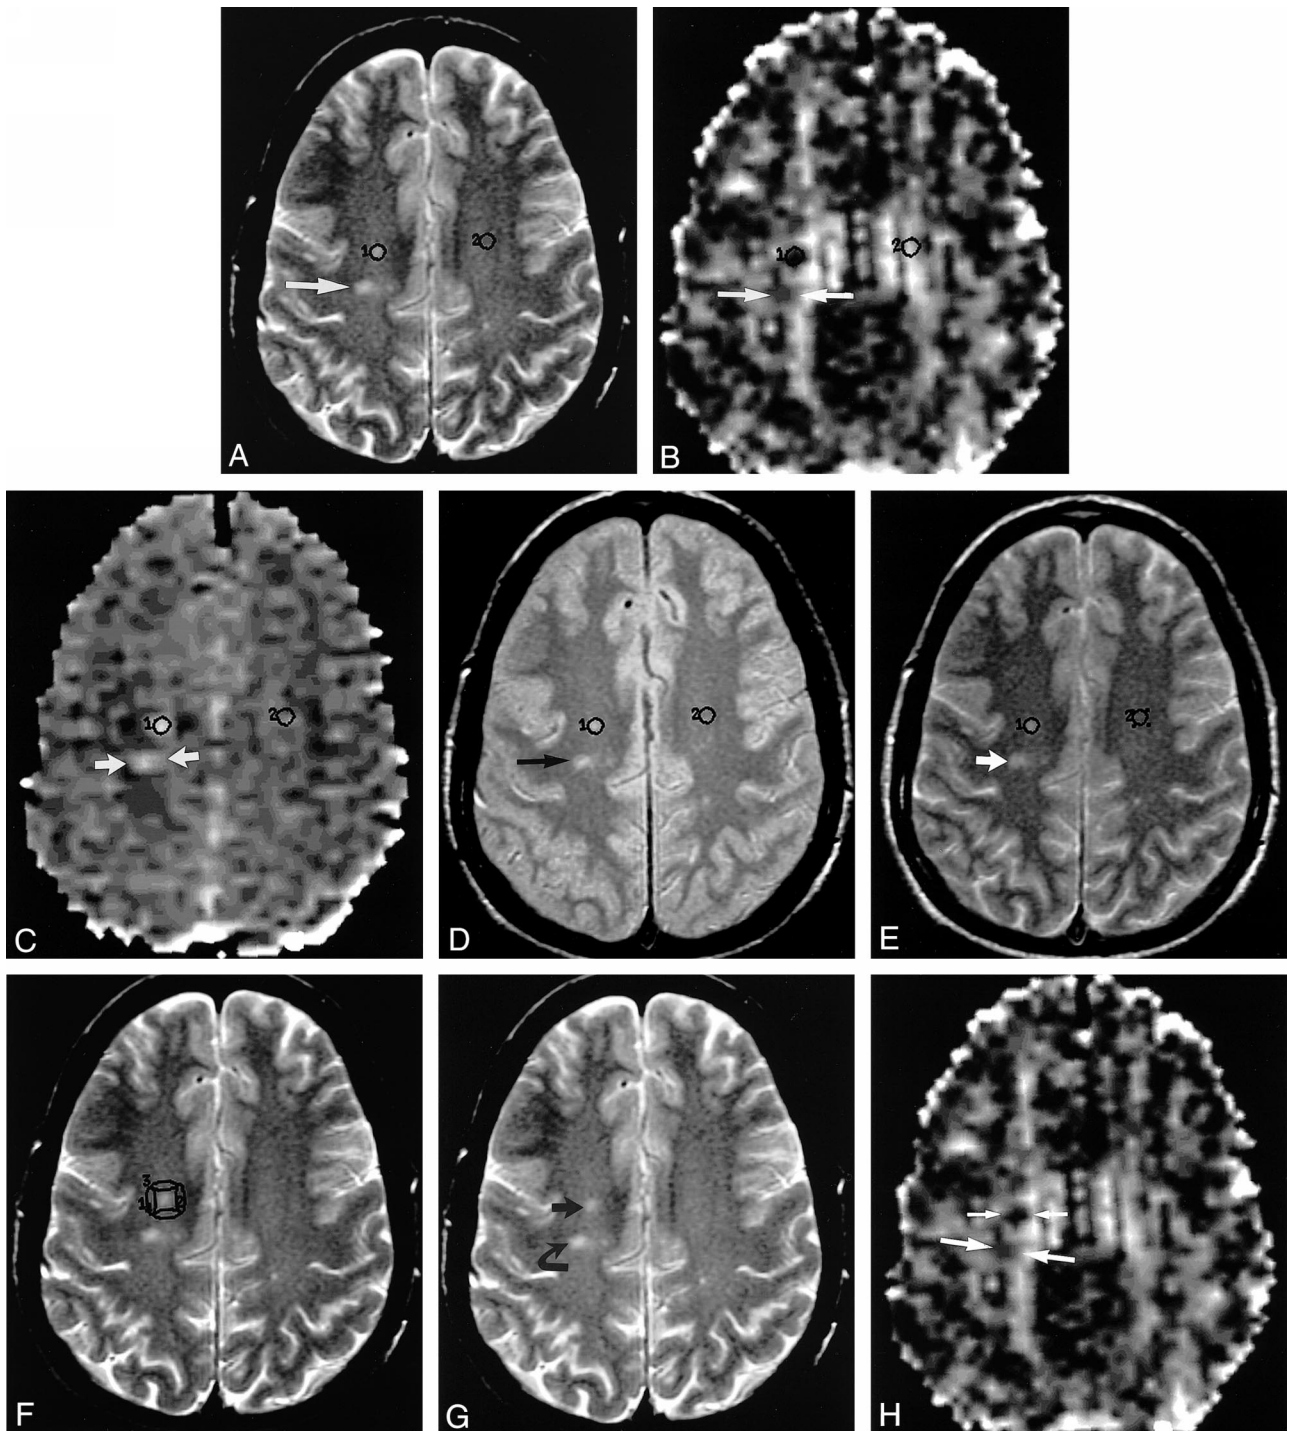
Axial MR images in a 42-year-old patient with MS.
